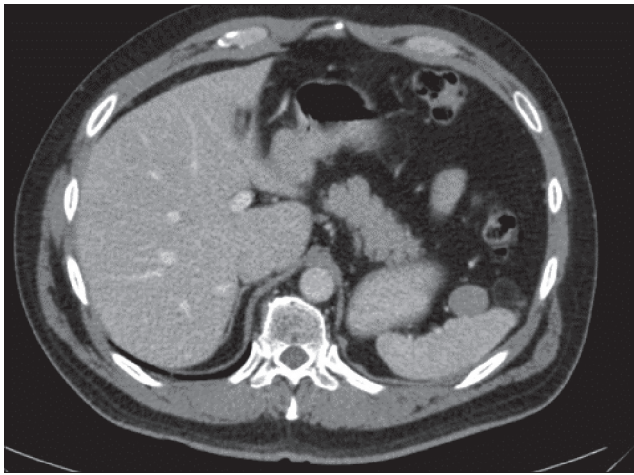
Enhanced computed tomography showing the tumor adjacent to splenic hilum
